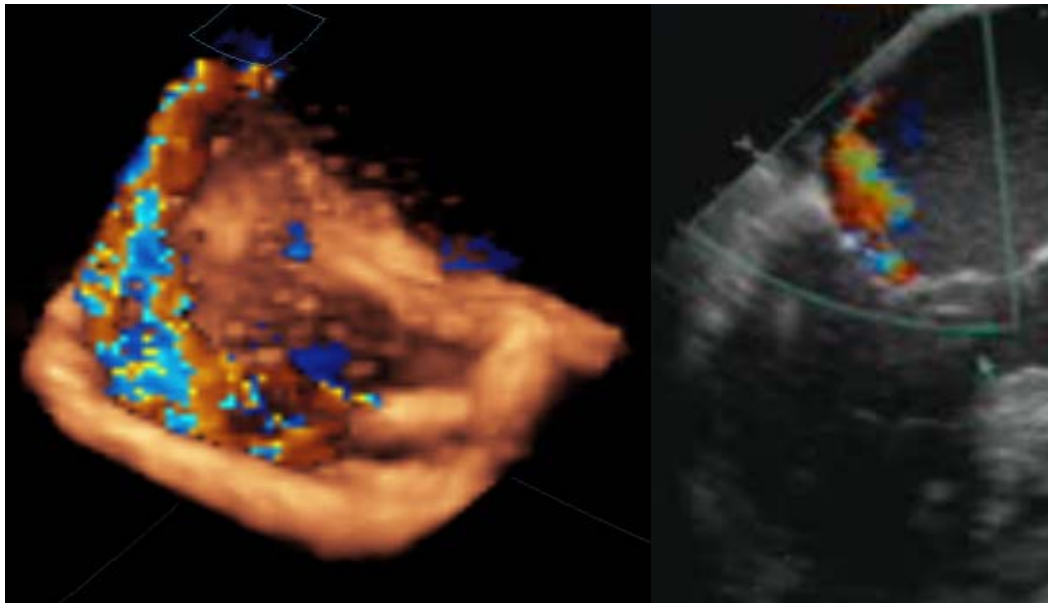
(A) 3D color Doppler acquisition of the in vitro valve model depicting the eccentric regurgitation jet riding along the anterior leaflet of the valve; (B) A color Doppler acquisition from a patient with isolated posterior leaflet prolapse, depicting the same eccentric jet as observed in vitro
